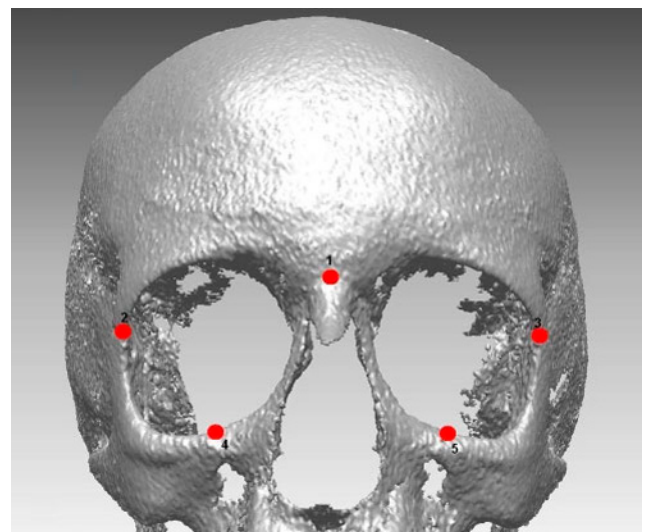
Five anatomical skull landmarks used for multitemporal registration of cone beam CT data, from T1 to T2. These landmarks are easily identifiable through X-ray images and are relatively stable through time
